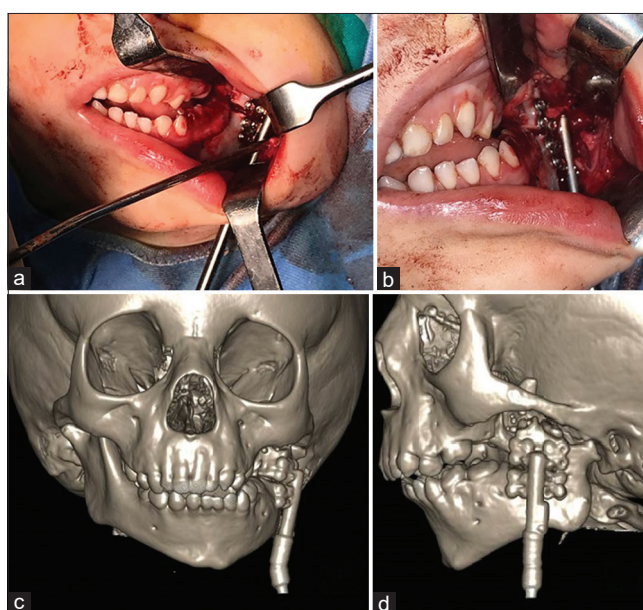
(a and b) Intraoperative views of the mandibular osteotomy and distractor placement. (c and d) Post-operative view of 3-dimensional computed tomography
